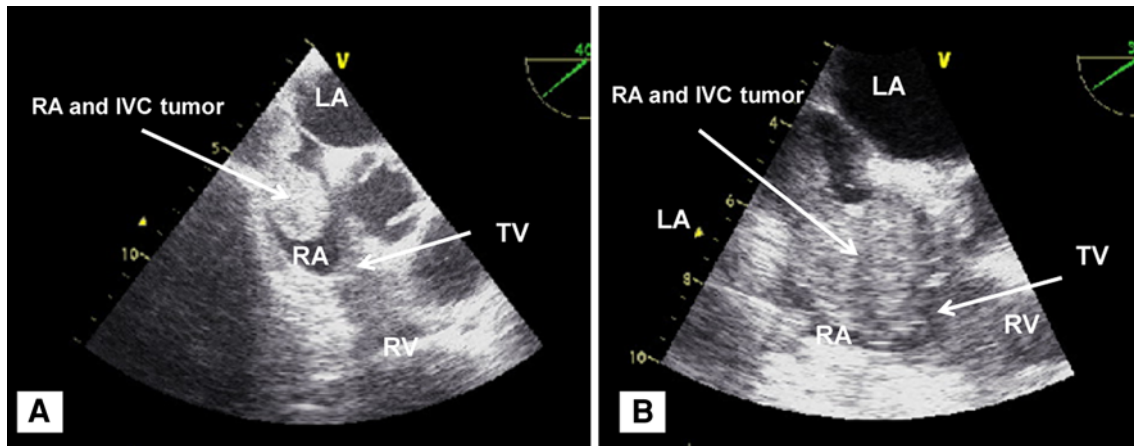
Transesophageal echocardiographic examination showed a tumor in the right atrium and opening of the inferior vena cava (a) (*arrows*). During ventricular tachycardia, the tricuspid valve was
